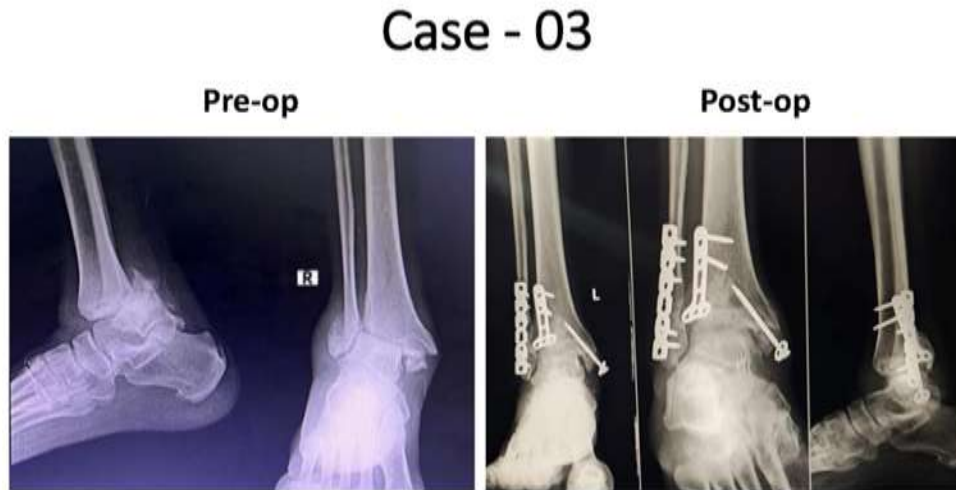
Radiographs of Case 03
